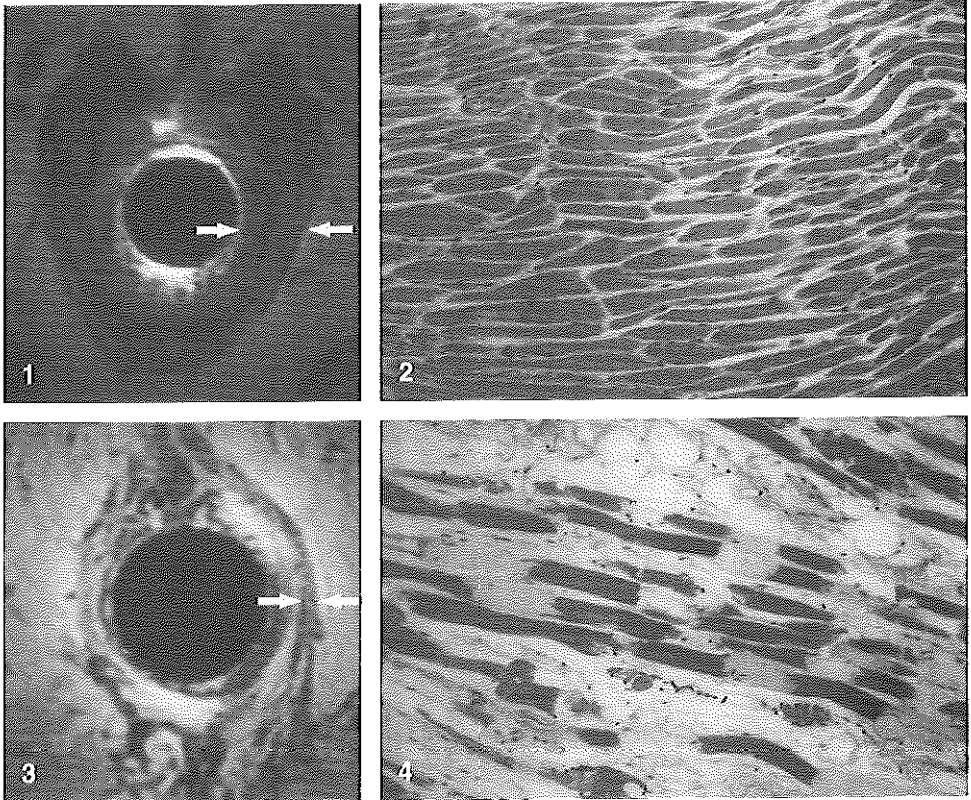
Normal external anal sphincter on endoanal MRI with anterior defect. *Arrows* relatively dark gray external anal sphincter
